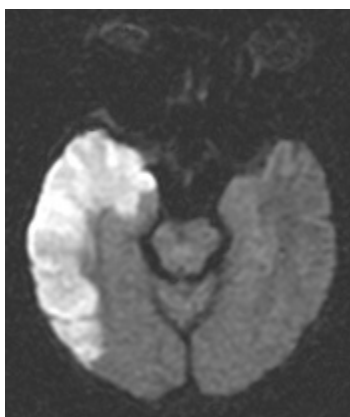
DWI showing hyperintensity of the right MCA territory due to acute infarction.
